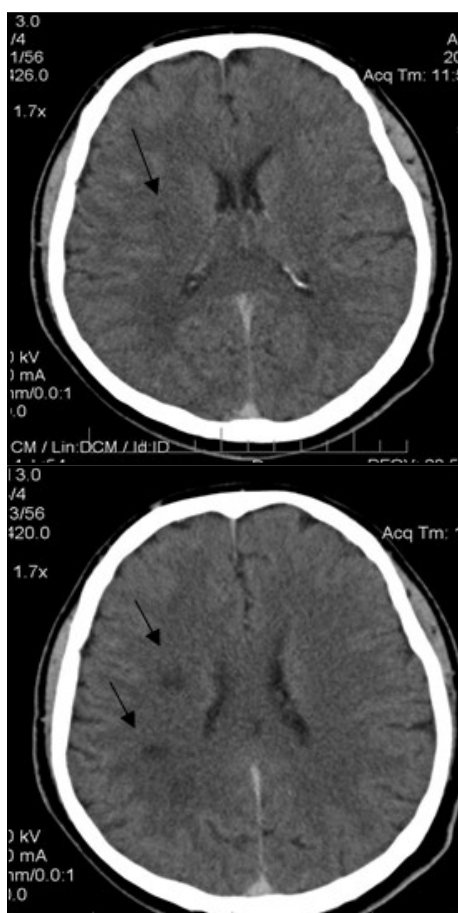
Native cerebral CT scan showing old ischemic lesions
